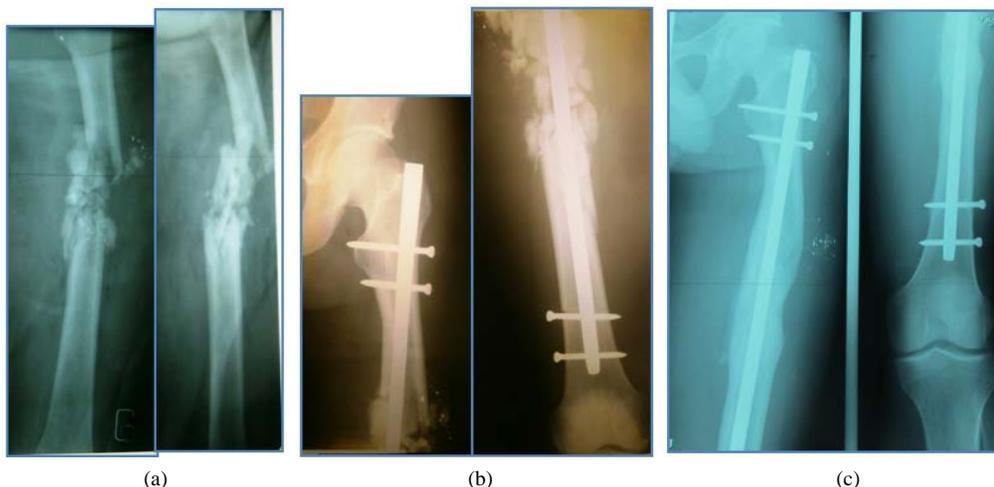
A 36-year-old male, civilian, sustained gunshot induced femur fracture without associated injuries. (a) Anteroposterior and lateral radiographs showing a comminuted femoral fracture. (b) Immediate debridement and internal fixation (interlocking nailing). (c) Union of the fracture at 35 weeks post operative.
